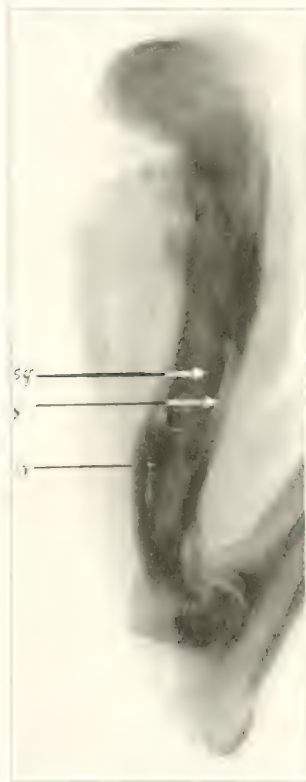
Roentgenogram of humerus, Nov. 3, 1919. Croton oil was inserted into the medullary canal in capillary tube containers, Oct. 10, 1919: *SQ*, sequestrum; *In*, involucrum; *S*, separation zone.
